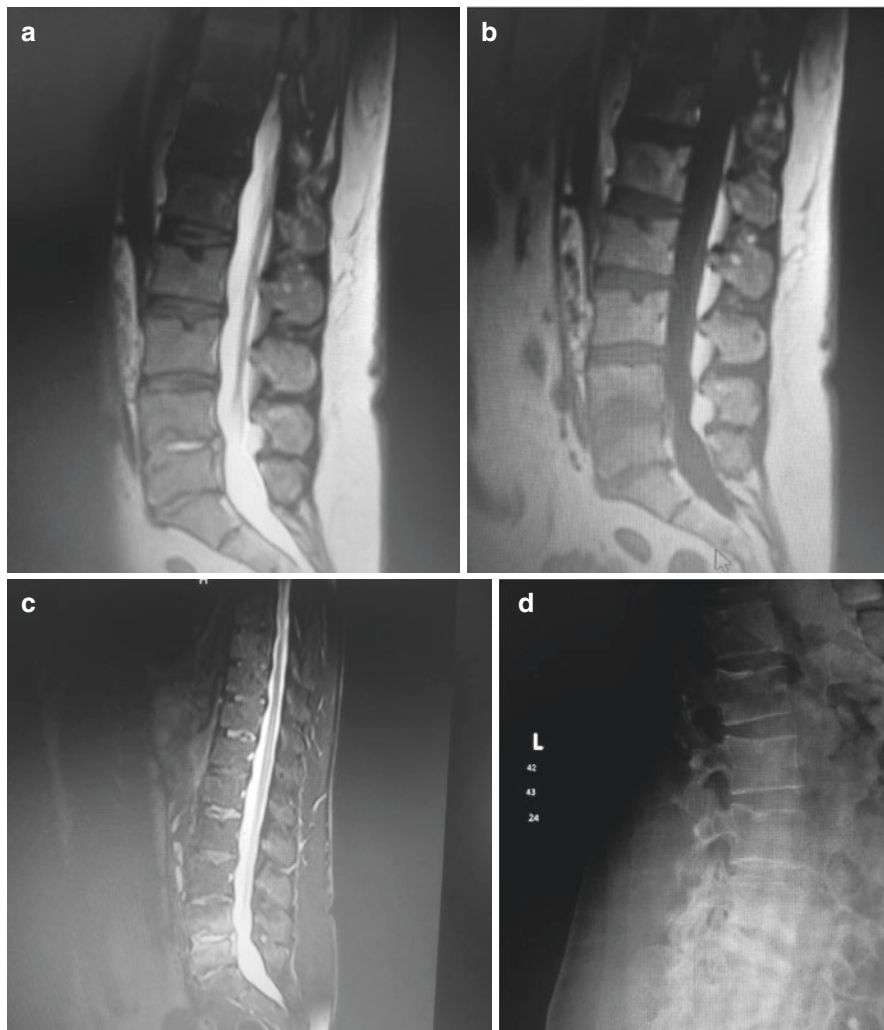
(a) T2 weighted sagittal MRI scan of the lumbar spine of a 53-year-old lady with rheumatoid arthritis and a non-healing ulcer on her foot. She presented with low back pain, and MRI scan reveals discitis at L4/5. Note the high signal within the disc space. (b, c) T1 weighted MRI scan of the above patient along with (c) a fat suppressed STIR sequence revealing the marrow changes in the adjacent vertebrae secondary to the infection. (d) Lateral X-ray of the same patient showing sclerosis of the end plates with loss of definition of the end plate secondary to the discitis. The plain X-ray may take some time to show changes of infection. (e) Healed discitis showing ankylosis of the L4/5 disc in the same patient
